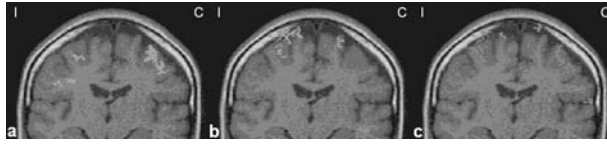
Activation map superimposed on coronal anatomical MR images in a right-handed subject, in response to passive stimulation. (a) Skin to skin. (b) Perception of a tactile stimulation. (c) Skin to skin with a skin-care product. I: Ipsilateral, C: Contralateral.¹³
